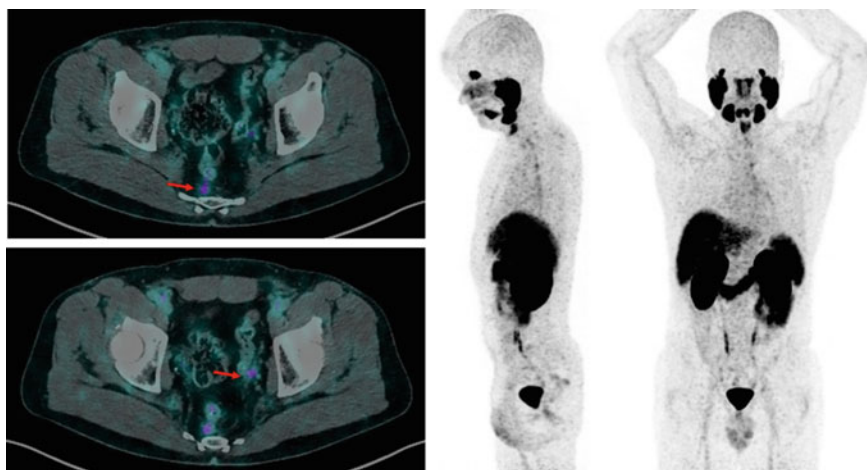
Anterior and lateral MIP views of ^{68}Ga -PSMA PET/CT in a PCa patient with biochemical relapse having a very low trigger PSA (0.41 ng/ml) after radical prostatectomy; red arrows indicate the locations of nodal involvements, respectively, at the presacral and left obturator region
